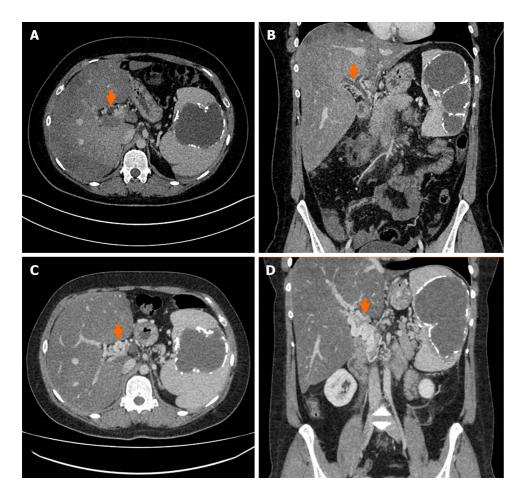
Cross-sectional images of recent portal vein thrombosis and subsequent cavernoma formation. A: Axial computed tomography demonstrating acute portal vein thrombosis (Orange arrow) with altered hepatic parenchymal attenuation secondary to ischaemia; there is an incidental large splenic cyst; B: Coronal computed tomography demonstrating acute portal vein thrombosis (Orange arrow) with altered hepatic parenchymal attenuation secondary to ischaemia; there is an incidental large splenic cyst; C: Axial computed tomography 6 months later in the same patient, demonstrating formation of portal vein cavernoma (Orange arrow); D: Coronal computed tomography 6 months later in the same patient, demonstrating formation of portal vein cavernoma (Orange arrow).
